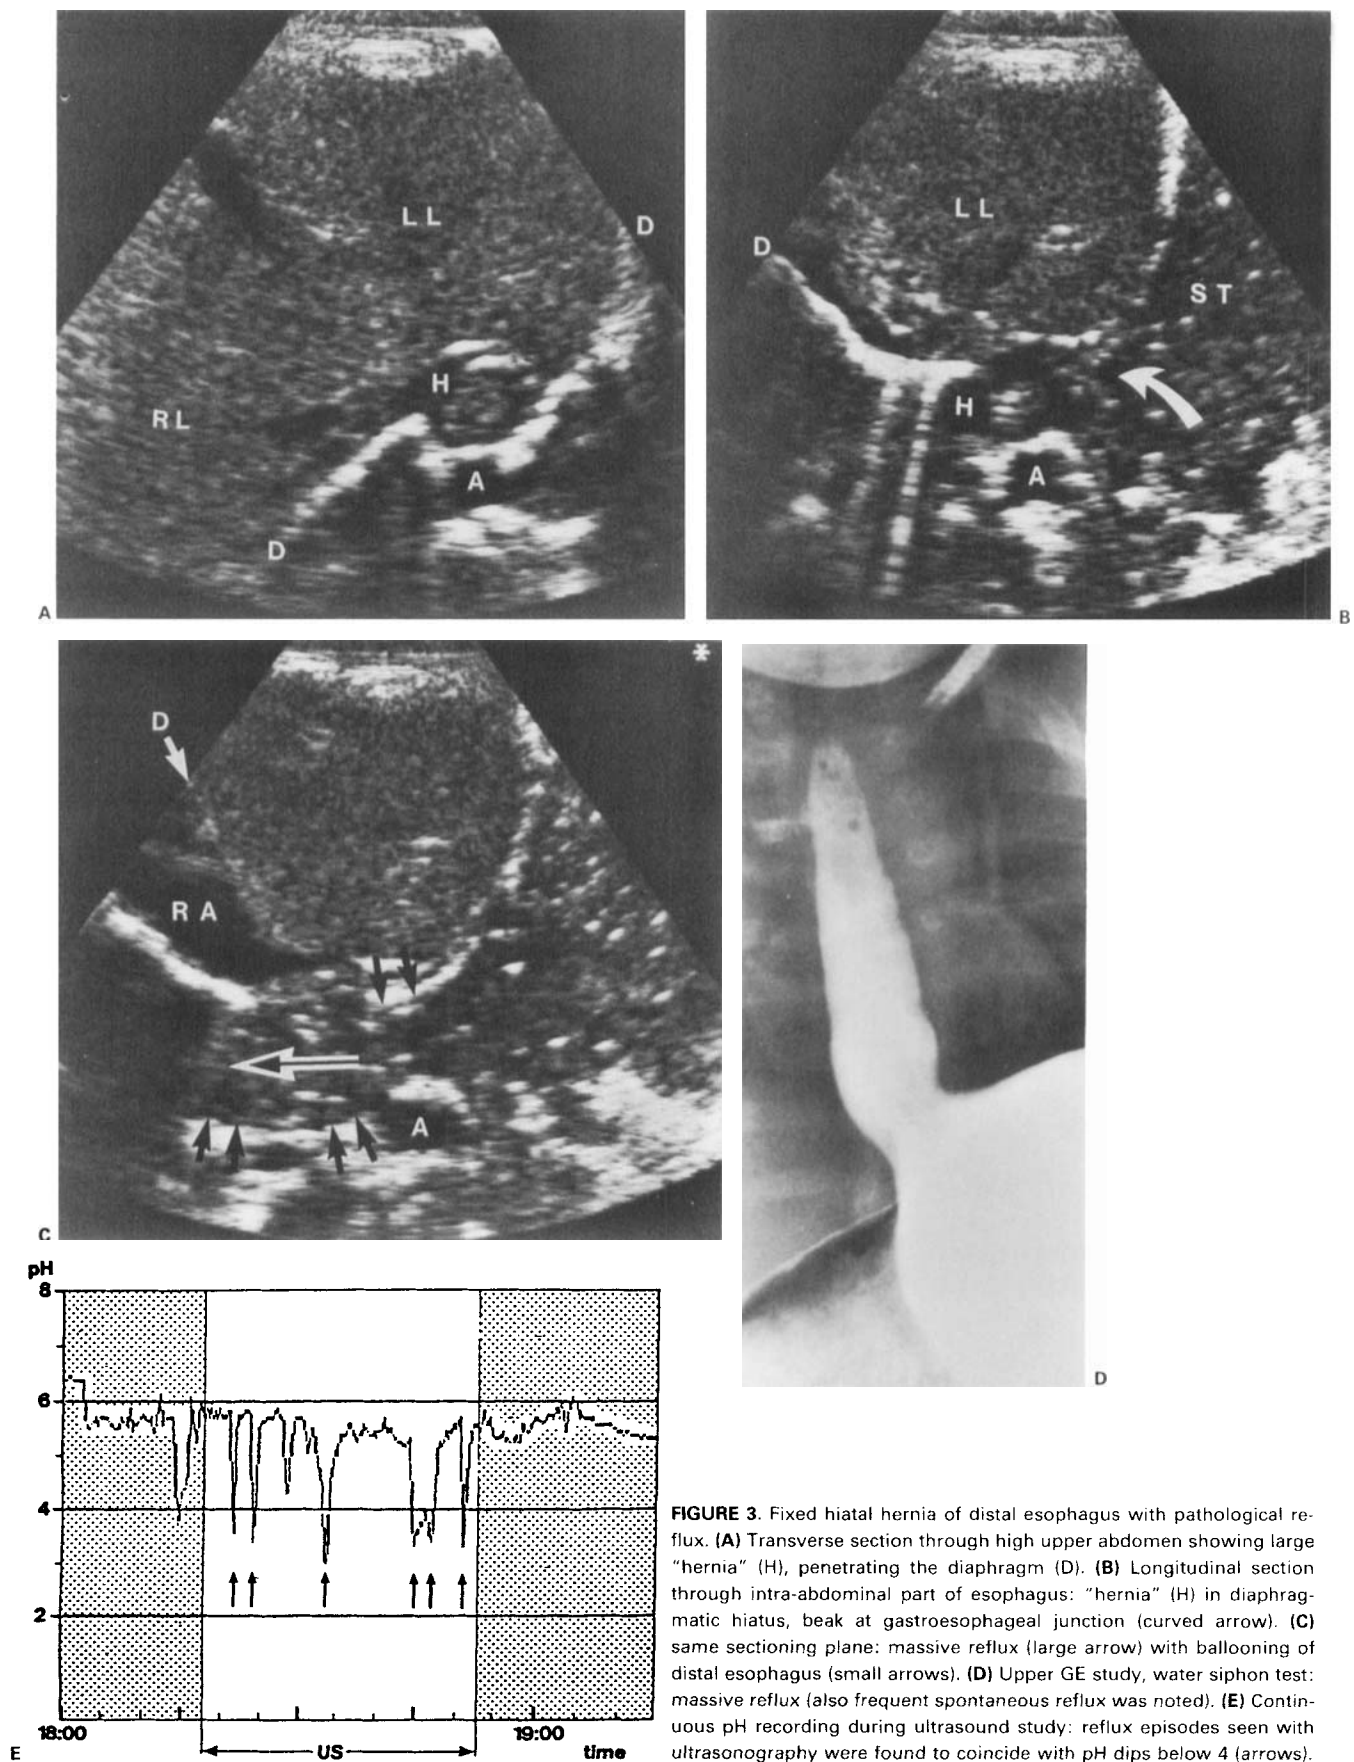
Fixed hiatal hernia of distal esophagus with pathological reflux. (A) Transverse section through high upper abdomen showing large "hernia" (H), penetrating the diaphragm (D). (B) Longitudinal section through intra-abdominal part of esophagus: "hernia" (H) in diaphragmatic hiatus, beak at gastroesophageal junction (curved arrow). (C) same sectioning plane: massive reflux (large arrow) with ballooning of distal esophagus (small arrows). (D) Upper GE study, water siphon test: massive reflux (also frequent spontaneous reflux was noted). (E) Continuous pH recording during ultrasound study: reflux episodes seen with ultrasonography were found to coincide with pH dips below 4 (arrows).
